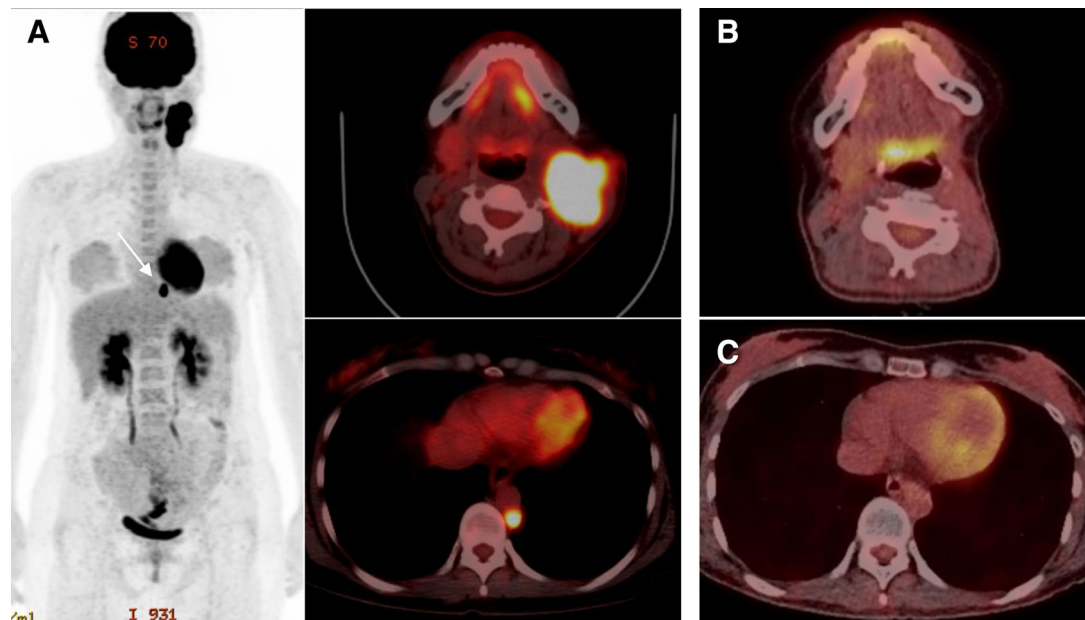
Radiological features of patients NUT carcinoma (NC) 3. (A): An initial positron emission tomography (PET)/computed tomography (CT) scan showed hypermetabolic lesions located in the left submandibular gland area and para-aortic lymph node (white arrow). After gross total resection of the primary and metastatic tumors, followed by adjuvant chemotherapy and radiotherapy, no evidence of remaining tumor was detected in the neck (B) or para-aortic area (C).
